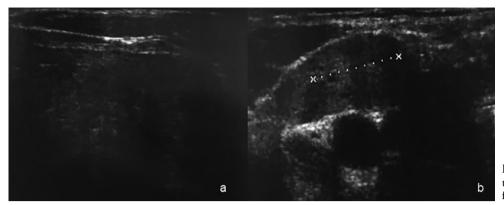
A): ultrasonographic features of the left lobe nodule;B)ultrasonographic features of lymph node metastasis.
